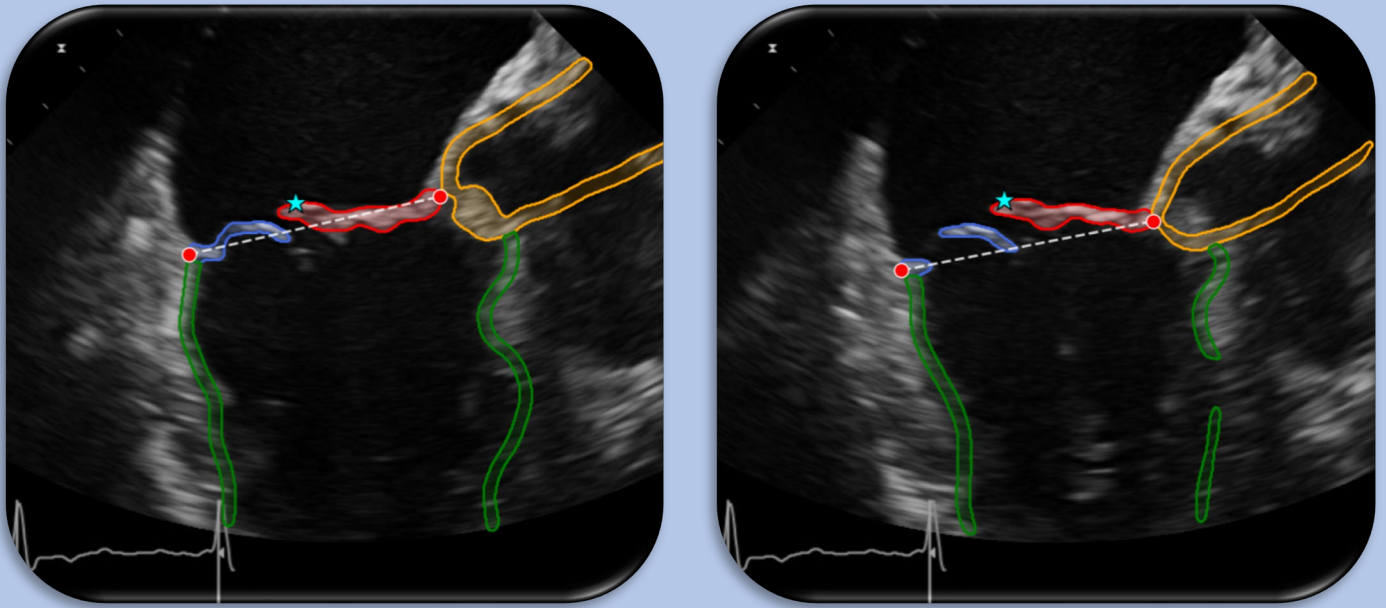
represent a patient with an A2 prolapse of the mitral valve. In this case, the prolapse was successfully detected by the algorithm using intraoperative echocardiography. These automated findings were consistent with the intraoperative surgical report, which described a significant prolapse of the A2 segment extending slightly into the A3 segment.
